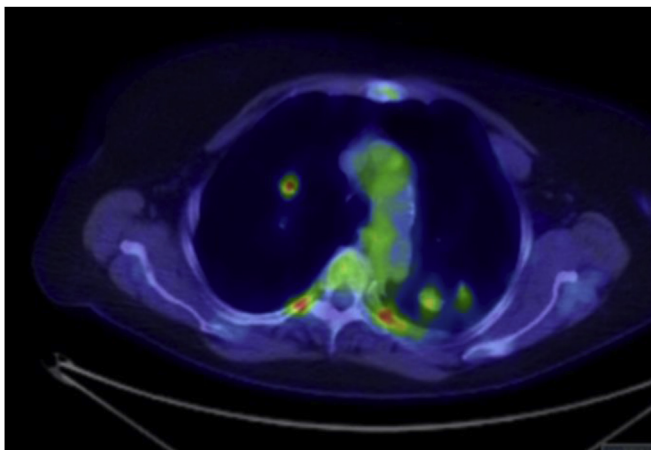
PET- CT slice at the equivalent level showing bilateral FDG – avid pulmonary nodules.
